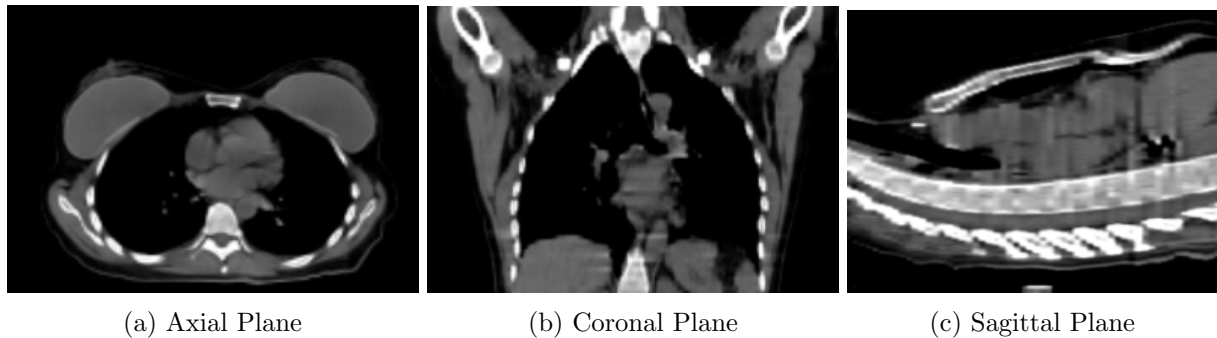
Visualization of a chest CT examination with 63 axial slices of a 48-year-old female patient, using the full range of Hounsfield units and automatically adapting them to the grayscale. (a) Visualization of a chest CT image with axial slice, using the window of $[-1000, 1000]HU$. (b) Coronal plane with window between $-100HU$ to $300HU$. (c) Sagittal plane with window between $-100HU$ to $300HU$.
